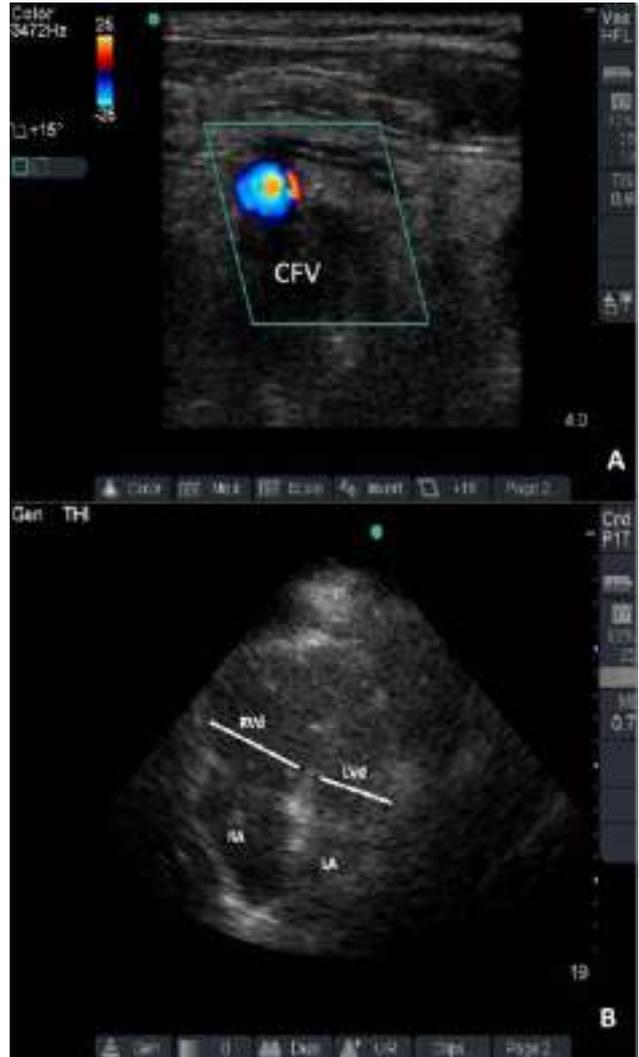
A) B-mode ultrasonography image (with the addition of color flow Doppler) of the right common femoral vein (CFV) and artery with compression. The CFV is still visible with compression and no venous flow. B) Apical four chamber of the heart with right ventricle strain as determined by qualitatively comparing the ratio of RV/LV and determining whether RV/LV <1.
